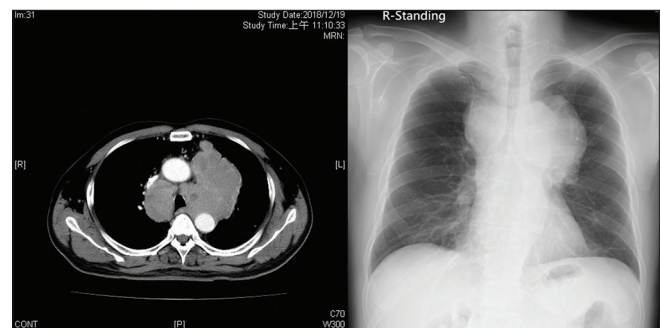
Chest computed tomography showed an enlarged mediastinal confluent mass. The size of the tumor increased from 7.8 cm to 8.7 cm in diameter. The change in tumor size was also observed on a chest X-ray
